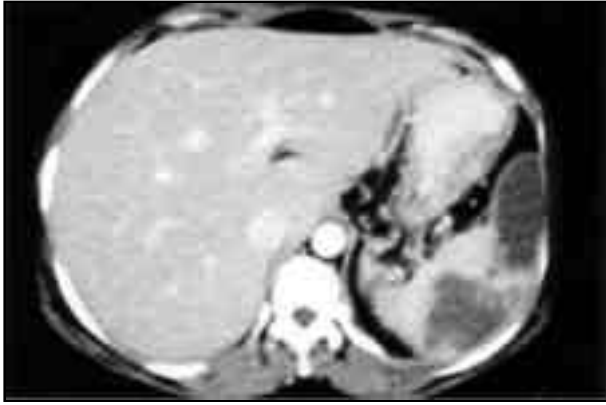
CT abdomen with oral and I.V. contrast showing post-operative infarcts in the spleen
